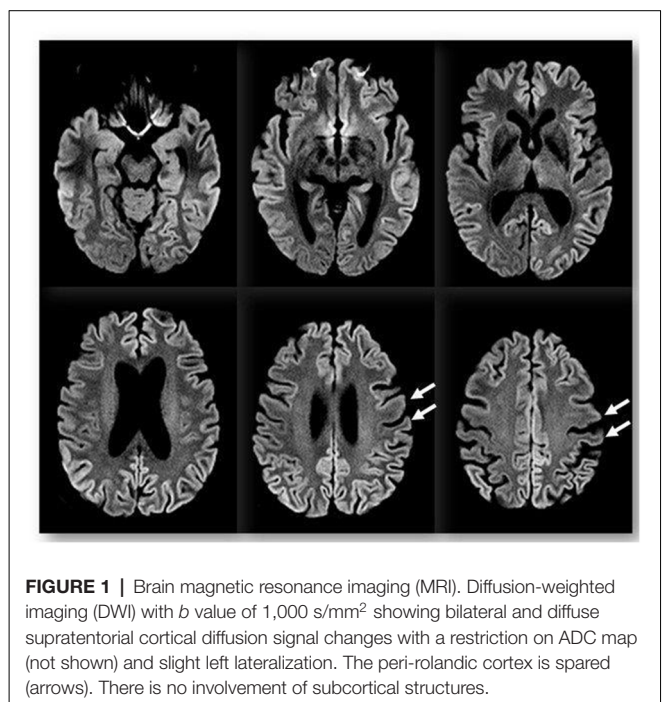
Brain magnetic resonance imaging (MRI). Diffusion-weighted imaging (DWI) with b value of 1,000 s/mm² showing bilateral and diffuse supratentorial cortical diffusion signal changes with a restriction on ADC map (not shown) and slight left lateralization. The peri-rolandic cortex is spared (arrows). There is no involvement of subcortical structures.
